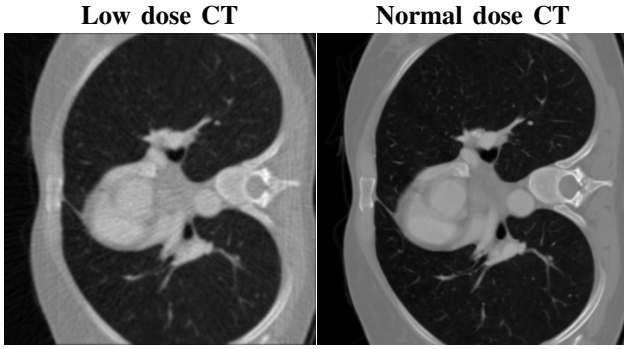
Samples of low-dose (left) and normal-dose (right) chest CT scans from the LoDoPaB-CT dataset used in this work. Both samples were reconstructed with the regular Filtered Back-Projection (FBP) technique.
